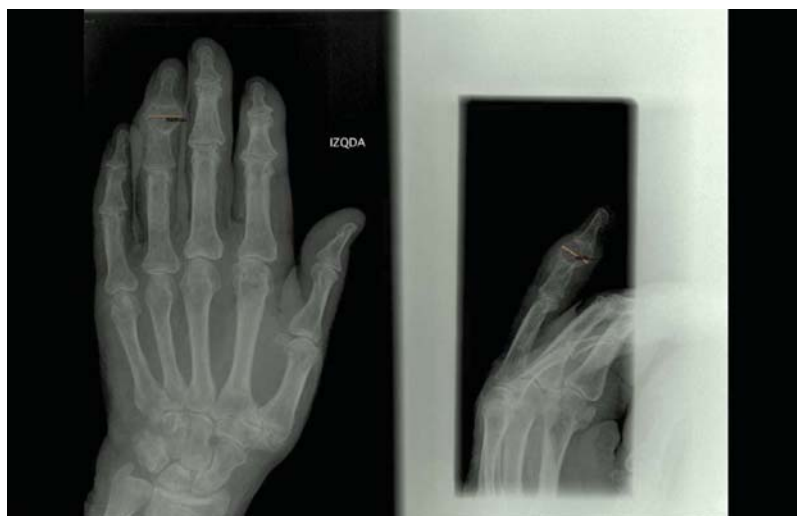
Posteroanterior simple radiography showing the lesion diagnosed 2 years ago as an enchondroma. The tumor was located at middle phalanx of the fourth finger and measured in millimeters.
